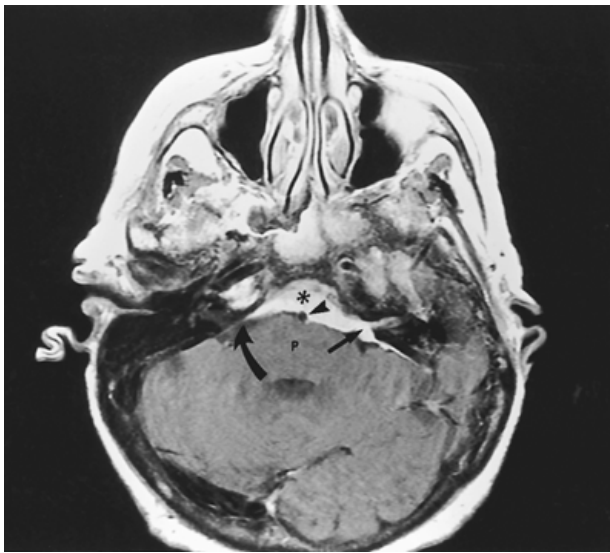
Meningioma. Axial T1-weighted magnetic resonance imaging following intravenous contrast injection. There is a broad, flat, enhancing lesion in the posterior fossa centered at the clivus and posterior petrous bone (asterisk). The mass occupies the prepontine cistern, compressing the pons (P), and partially encasing the basilar artery (arrowhead). It extends into the left cerebellopontine angle and internal auditory canal (arrow) but does not widen the porus acusticus. The lesion makes an obtuse angle with the petrous bone (curved arrow).
